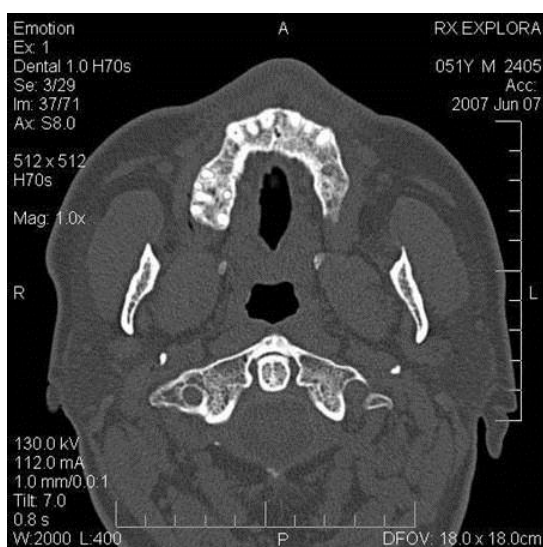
Pac CG. CT horizontal section.
